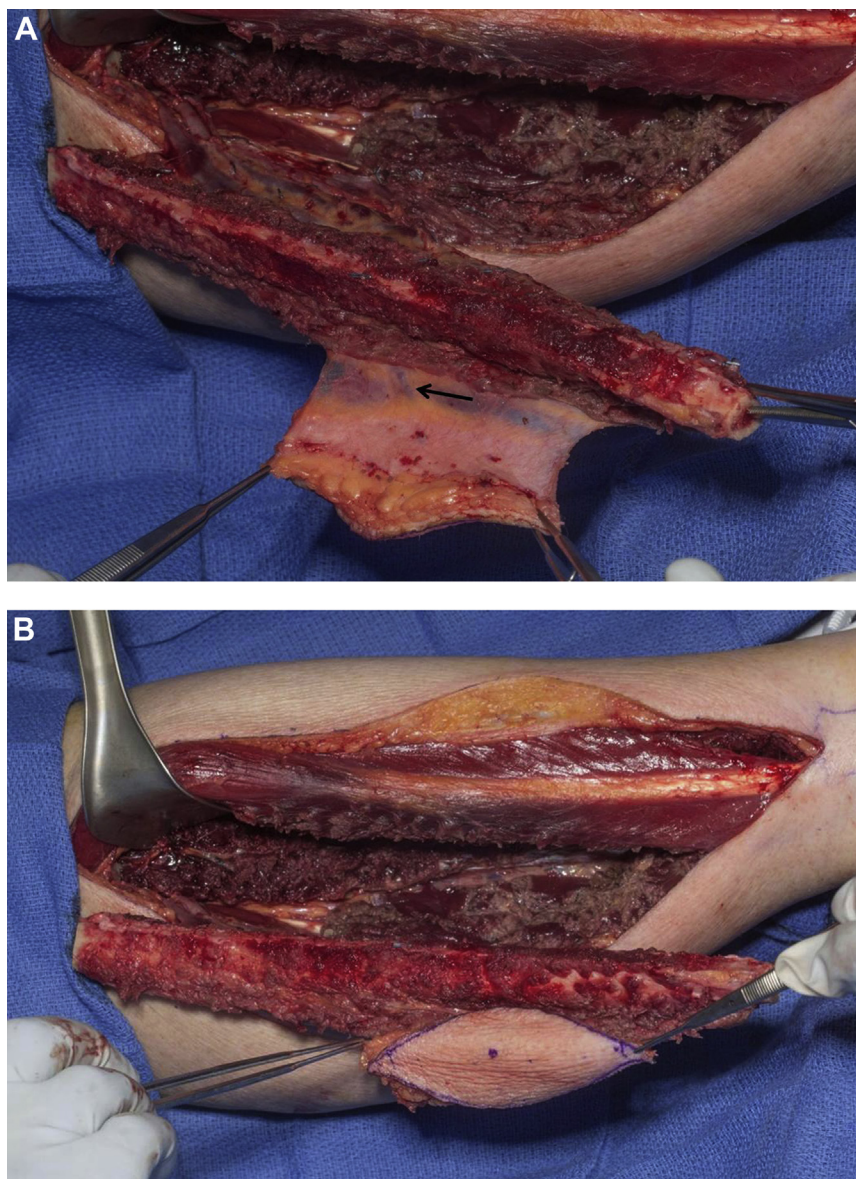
Intraoperative dissection of the right fibular free flap. A, Elevated fibular bone and skin paddle. Note the oblique course of the perforator through the posterior crural septum toward the skin (black arrow). B, Blue marking on the skin paddle corresponding to the intraoperative transcutaneous handheld Doppler verification of the perforator. (Fig 4 continued on next page.)
